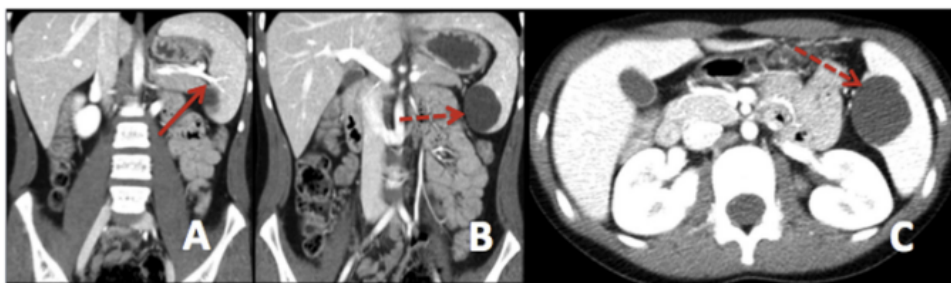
(A) CT angiogram showing the splenic artery (red arrow) and (B,C) the splenic lower pole cyst (red dashed arrow).
